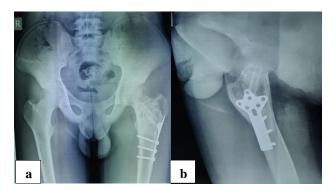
AP and lateral radiographs showing final follow up at 18 months with healed simple bone cyst with well incorporated bone graft.
